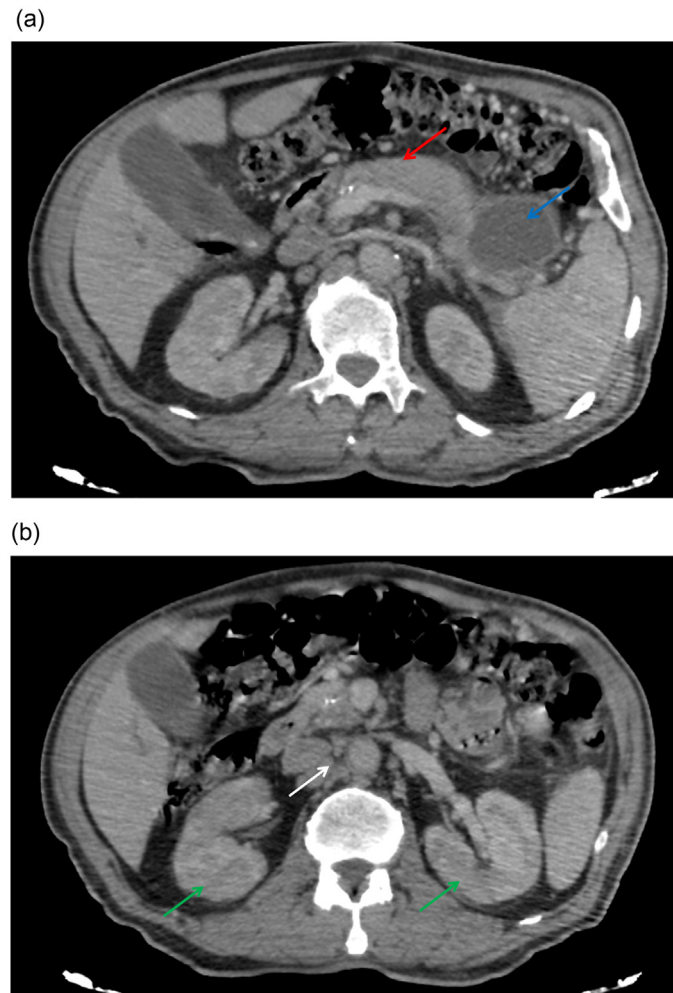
Axial contrast-enhanced CT images (A, B) showing: (A) swollen pancreas with loss of lobulations and a "sausage-like" appearance (red arrow), along with a simple cystic lesion in the pancreatic tail (blue arrow). (B) Bilateral peripheral renal lesions, triangular and hypodense (green arrows), and enlarged lymph nodes in the peripancreatic regions (white arrow).
